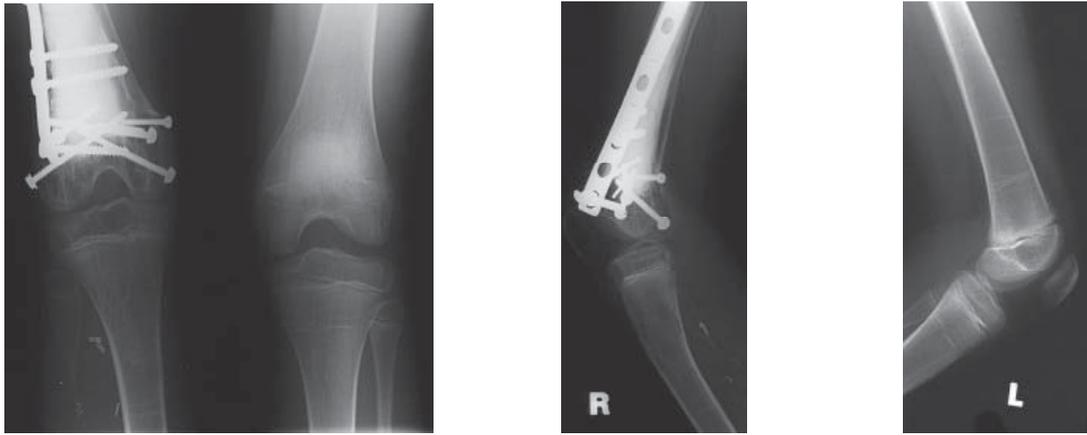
X-rays taken 5 years following surgery showing continued development of the right knee joint despite sacrifice of the pphysis (Patient 5).
